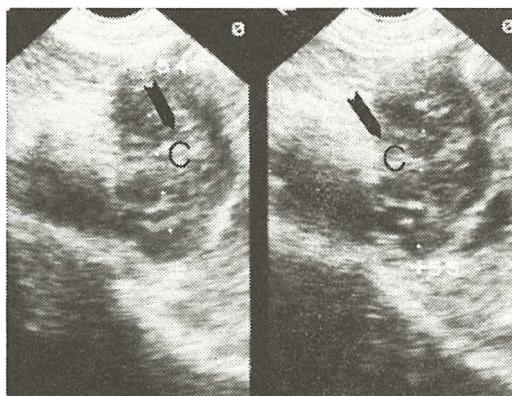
Sonographic scan of transverse colon cancer (C)
